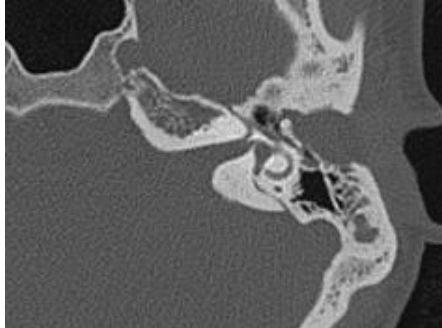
Axial temporal bone CT image- the soft-tissue mass filling the inferior EAC, medially pushed ossicles.
